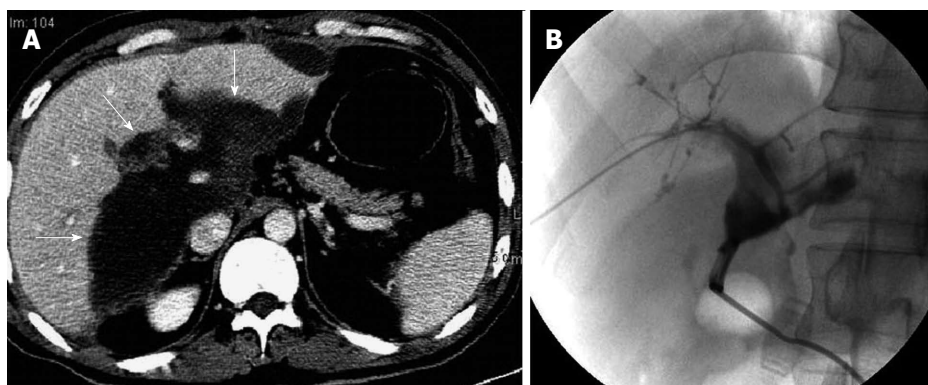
A 32-year-old man with fever due to anastomotic bile leakage 12 d after orthotopic liver transplantation. A: Transverse computed tomography image in the portal venous phase shows a bulk of fluid collection at the hepatic hilar region (arrow); B: Percutaneous transhepatic cholangiography demonstrates anastomotic bile leakage.
